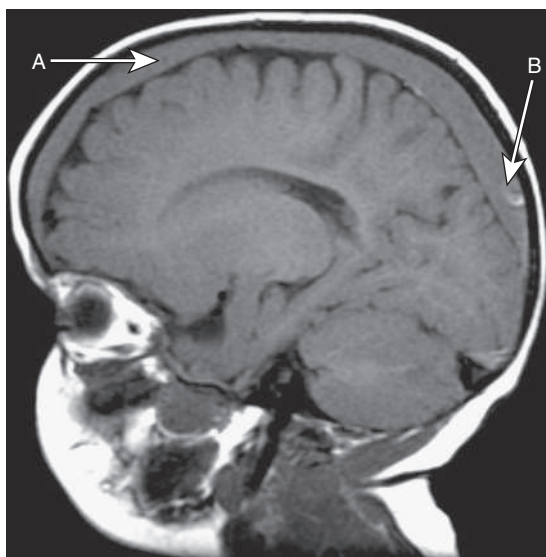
CT scan indicating intracranial bleeding. A, Older blood. B, New blood.
